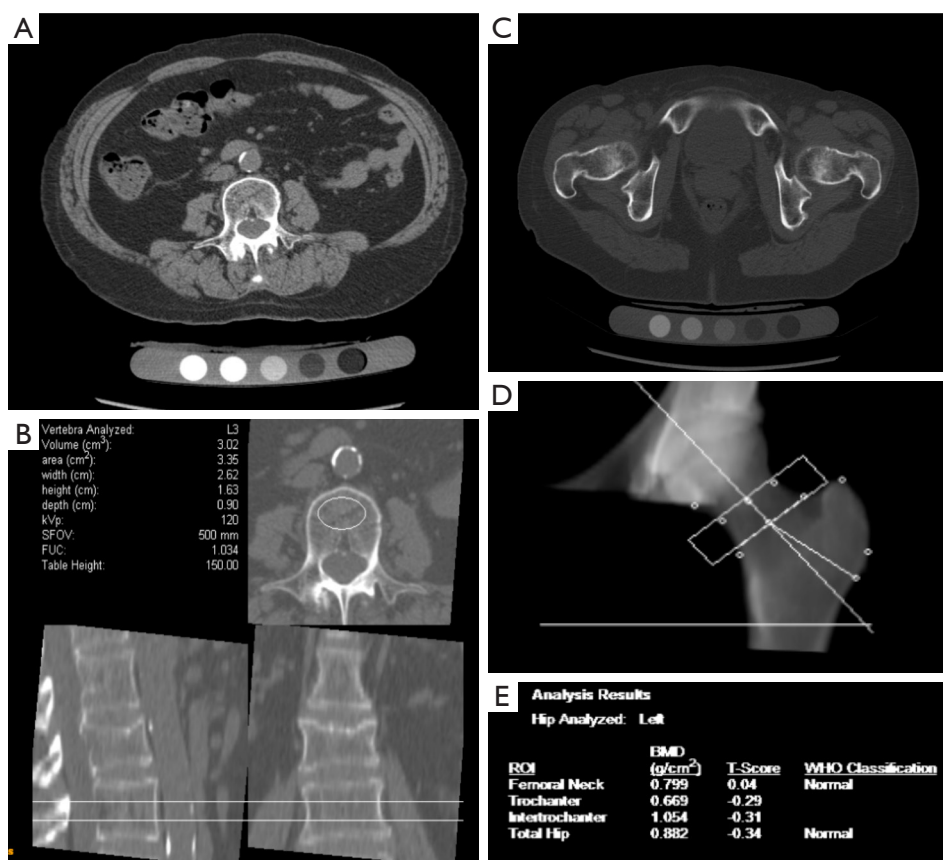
Quantitative computed tomography (QCT) of the lumbar spine and the hip. Source image obtained in the lumbar spine of a 65-year-old female (A), with definition of region of interest in vertebra L3 yielding a BMD (68.4 mg/cc) in the osteoporotic range according to the guidelines of the American Board of radiologists (B). Source image obtained in the hip of a 76-year-old female (C), with definition of regions of interest in the left femoral neck (D) and subsequent bone mineral density (BMD) analysis showing normal bone densities (E). (Images courtesy of Thomas Link, MD PhD, University of California at San Francisco, Dept. of Radiology and Biomedical imaging).
